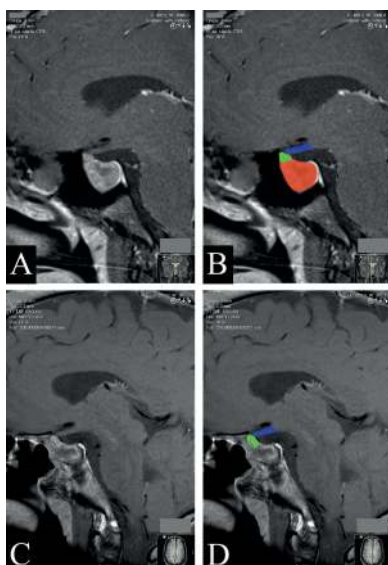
Coronal view A+B: preoperative T1 MRI. Adenoma (red + green), optic nerves (blue). C+D: postoperative T1 MRI. Optic nerves (blue), remnant (green)
